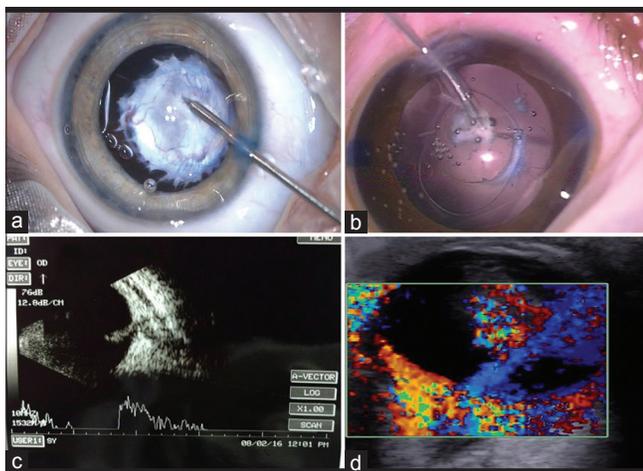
Persistent fetal vasculature (a) hemostasis using diathermy (b) Fugo's™ plasma blade (c) persistent fetal vasculature stalk on ultrasonography (d) color Doppler showing flow in persistent fetal vasculature
